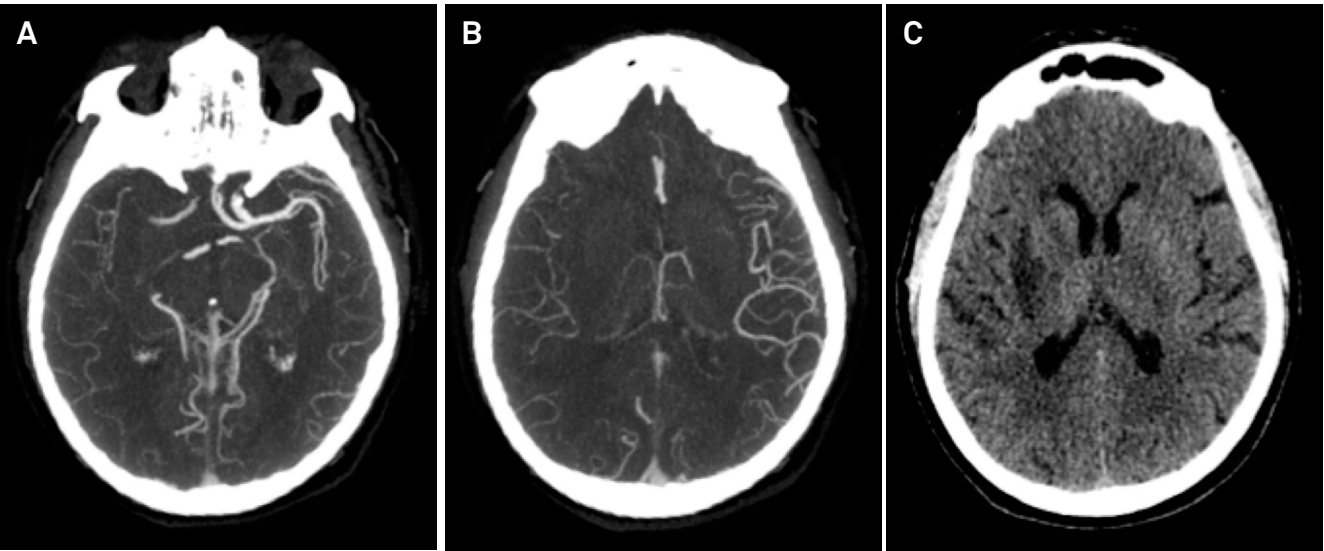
Proximal occlusion with suitable reconstitution of the distal middle cerebral artery (MCA) branches (Mittet grade 3). (A) Computed tomography angiography (CTA) identified right MCA occlusion. (B) Note collateral circulation throughout the MCA territory, filled from leptomeningeal branches. (C) Follow-up non-contrast compute tomography (NCCT) 24 hours later demonstrating a small final infarct volume confined to the lenticulostriate territory (proximal MCA); this patient exhibited a good clinical outcome.
